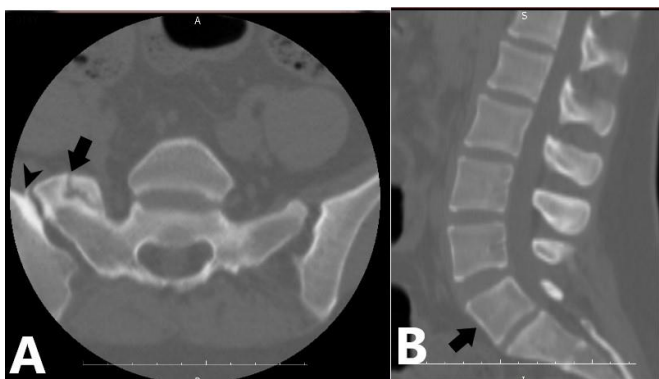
Sacralisation form of lumbosacral transitional vertebra in a 25 year old female patient on axial (A) and sagittal (B) computed tomography scan (thick arrows). Right sided osteitis condensans ilii is also seen on axial (A) computed tomography scan (arrow head).
